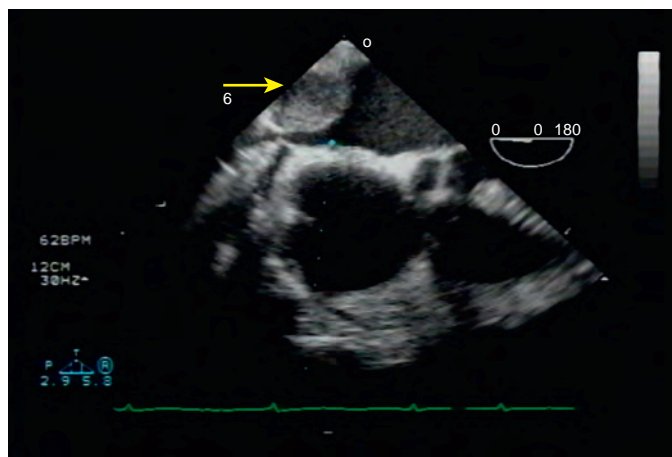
Modified four-chamber transesophageal echocardiographic (TEE) view at 0 degrees after surgical resection of the posterior mediastinal tumor. TEE shows that one lobe of the tumor (yellow arrow) remains adherent to the posterior left atrial wall. This was not initially evident to the surgeon.
